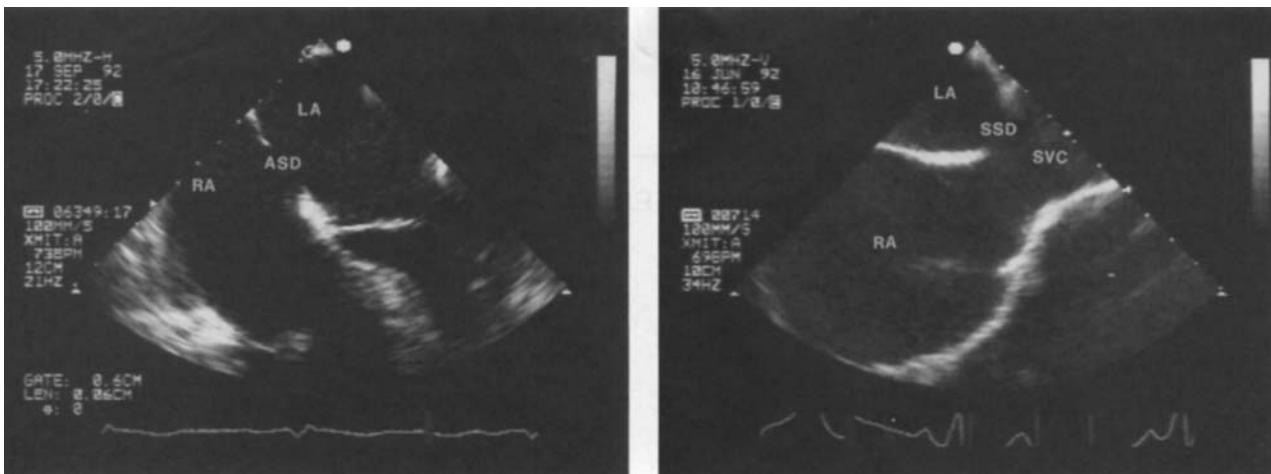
Transesophageal two-dimensional images from patients with an ostium secundum (A) and superior sinus (B) atrial septal defect. In (A) the defect is seen in the mid-portion of the inter-atrial septum in the fossa ovalis. In (B) the superior sinus defect (SSD) can be seen to be an 'overriding' of the superior vena cava (SVC) rather than a defect in the inter-atrial septum itself. (From Camm, J.D., Fox, A.J., Hall, R.J.C., and Poole-Wilson, P.A., Eds., *Diseases of the Heart*, second edition. London: W. B. Saunders, 327, 1996.)
